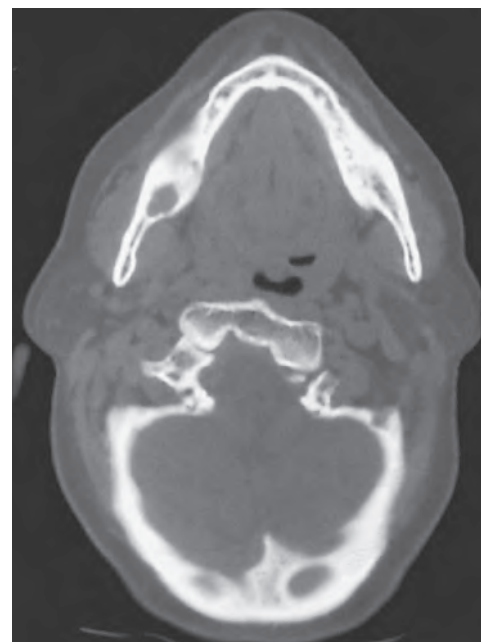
Brown tumor of hyperparathyroidism in the mandible showing a bone-destructive process on a panoramic x-ray (A) and CT scan (B) of the lesion shown in Fig. 16.162.
